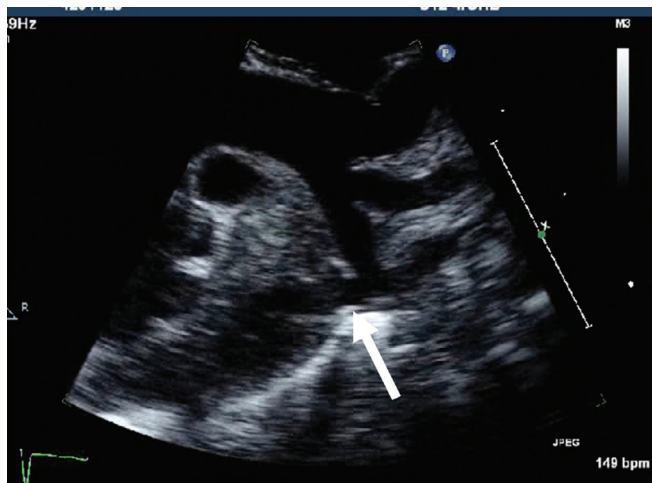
■ Discrete coarctation of the aorta on two-dimensional echocardiography and color Doppler imaging. Although there appears to be mild hypoplasia of the transverse arch, color Doppler does not reveal flow acceleration across this segment.
